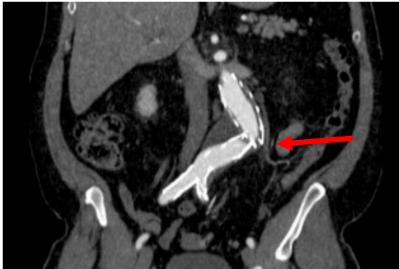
CT Scan of Endologix Device with Modular Disconnection¹⁸
